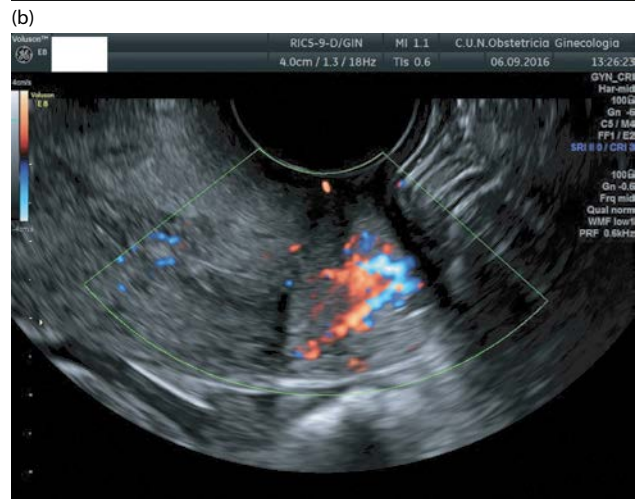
Transvaginal ultrasound showing an isoechoic cervical cancer (T) involving the posterior lip of the cervix. The cervical canal can be observed. However, the tumor limits are difficult to identify (a). The use of color Doppler allows a better definition of the tumor’s location (b).
